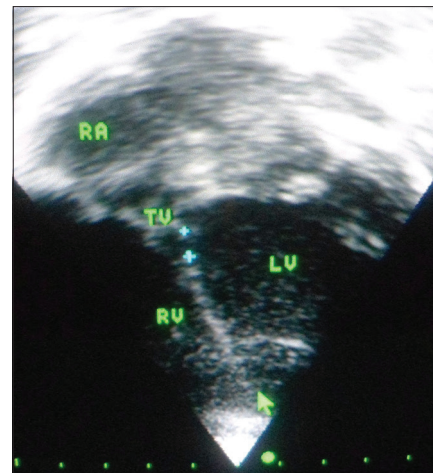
Echocardiogram showing a sub-aortic ventricular septal defect
